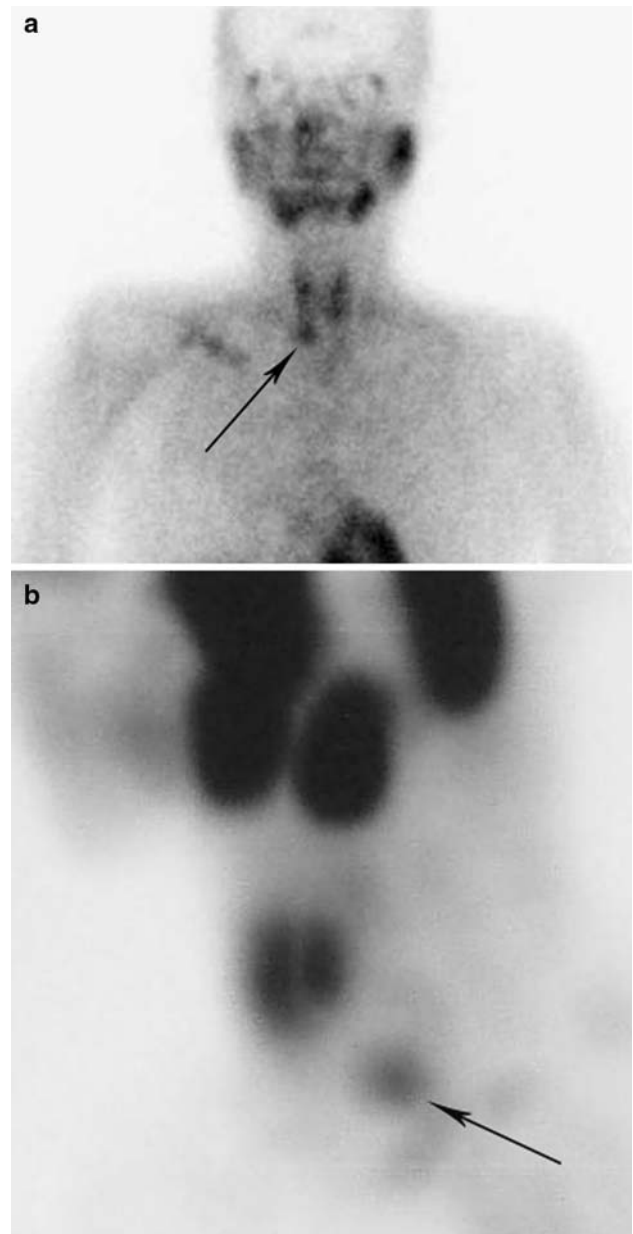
(a) ^{99m}Tc -sestamibi scintigraphy (dual phase): right parathyroid adenoma at the level of the inferior pole of the thyroid lobe (arrow). (b) ^{99m}Tc -sestamibi scintigraphy (SPECT images, profile): same parathyroid adenoma posteriorly located: position 2 (arrow)
